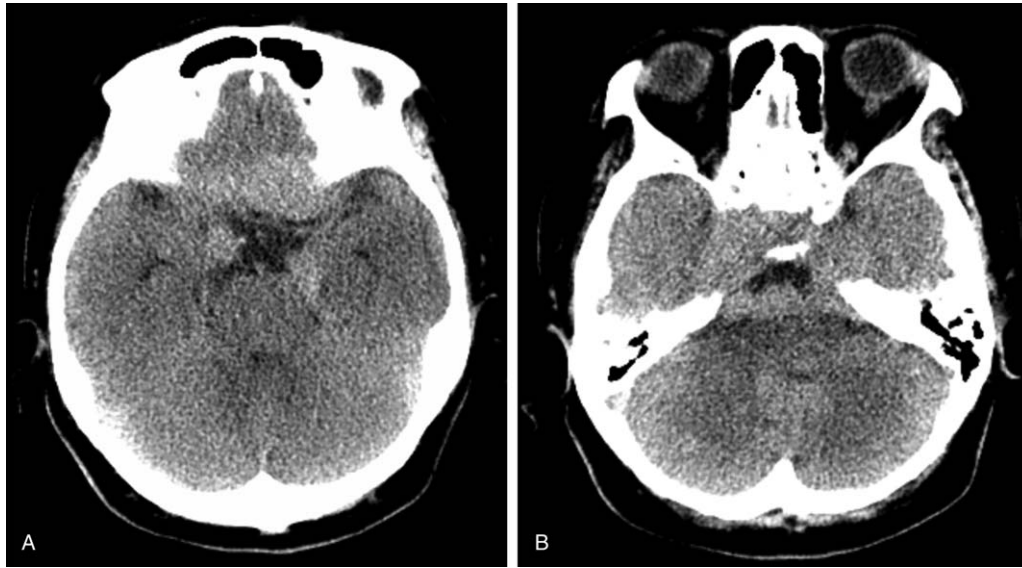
Brain computed tomography (CT) demonstrated multiple well-defined, homogenous, hyperdense masses in the basement of anterior-middle-posterior cranial fossa.
